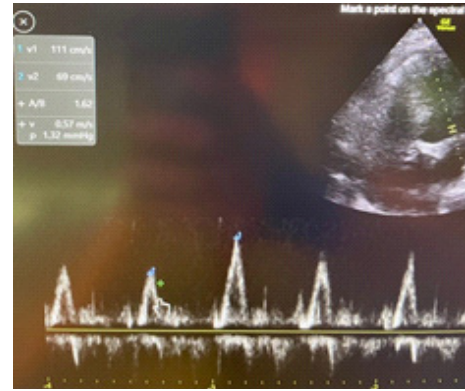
Bedside transthoracic echocardiography demonstrating >25% mitral valve inflow variation with respiration.
